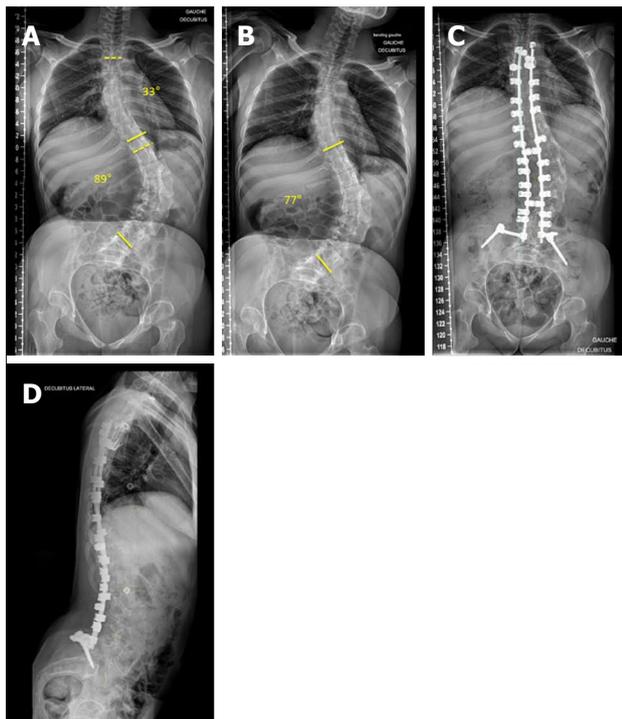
A 16-year-old girls with cerebral palsy (GMFCS IV). This non-ambulatory patient was operated on with band-only instrumentation. A: Pre-operative supine anteroposterior X-rays; B: Pre-operative supine left bending X-rays (reducibility of 13%); C: Post-operative supine anteroposterior X-rays; D: Post-operative supine lateral X-rays.
